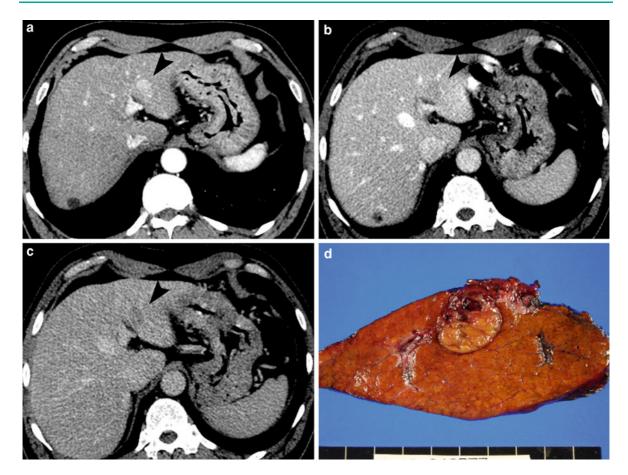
Small HCC of distinctly nodular type (small progressed HCC) showing typical enhancement pattern. a Arterial phase CT scan demonstrates a hyperenhancing nodule in segment 3 (*arrowhead*). b and c Portal phase (b) and delayed
